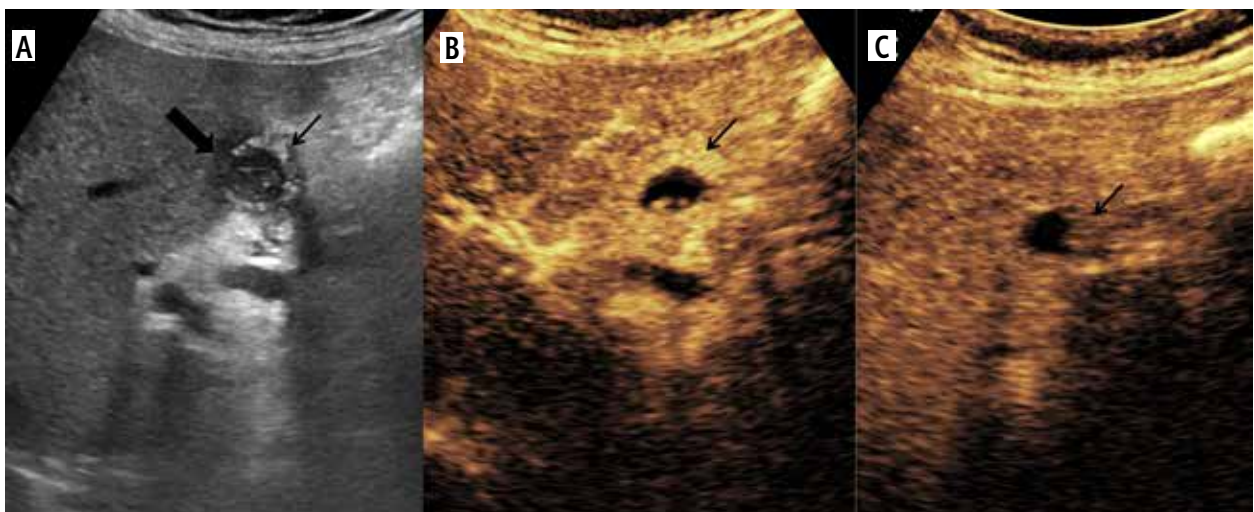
Enhancement characteristics of wall-thickening type of gallbladder cancer (GBC) in contrast enhanced ultrasound (CEUS). A) Gray-scale US image showing asymmetrical circumferential mural thickening involving the fundus and body of the gallbladder (arrow) with loss of interface with the adjacent liver parenchyma (thick arrow). B) Arterial phase image of the CEUS shows heterogeneous enhancement (arrow). C) There is early washout at 25 seconds (arrow)
